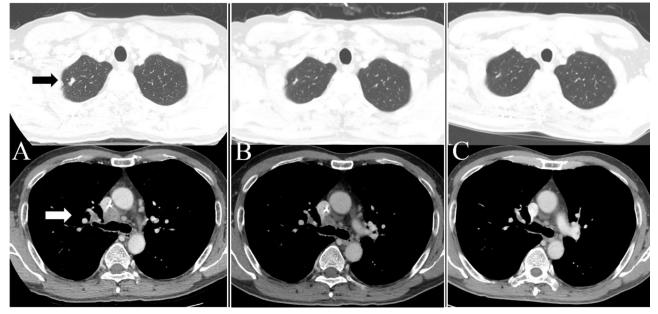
(A) A chest CT scan dated June 4, 2013 revealed an approximately 2 cm solid nodule in the upper right lobe and the enlargement of multiple mediastinal lymph nodes. (B) A follow-up chest CT scan dated August 28, 2013 showed marked shrinkage of the nodule and the mediastinal lymph nodes after only seven weeks of herbal medicine treatment. (C) A recent chest CT scan dated August 3, 2015 (chemoport removal) demonstrated the regression of lung metastases.
